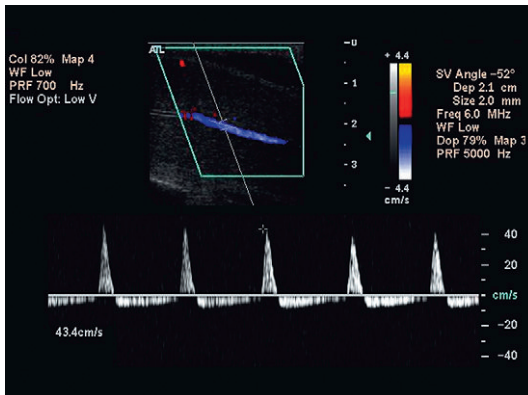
Spectral Doppler tracing at full rigid erection. Note further narrowing of the systolic inflow peak. Outflow continues through diastole but is at a lesser velocity (compared to Fig.11.7).
